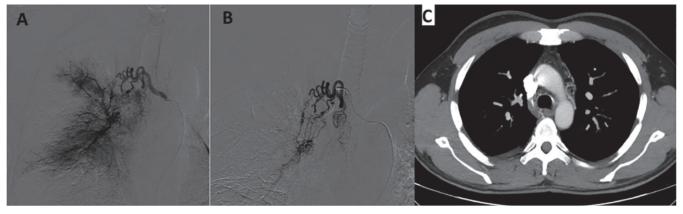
The images of digital subtraction angiography before and after embolisation and MIP reconstruction of thorax CT. Digital subtraction angiography images show enlarged and tortuous bronchial artery supplying the right middle lobe before (A) and after embolisation (B). The hypertrophic bronchial arteries can be also seen in the thick-section MIP (maximum intensity projection) reconstruction of thorax CT (C).
